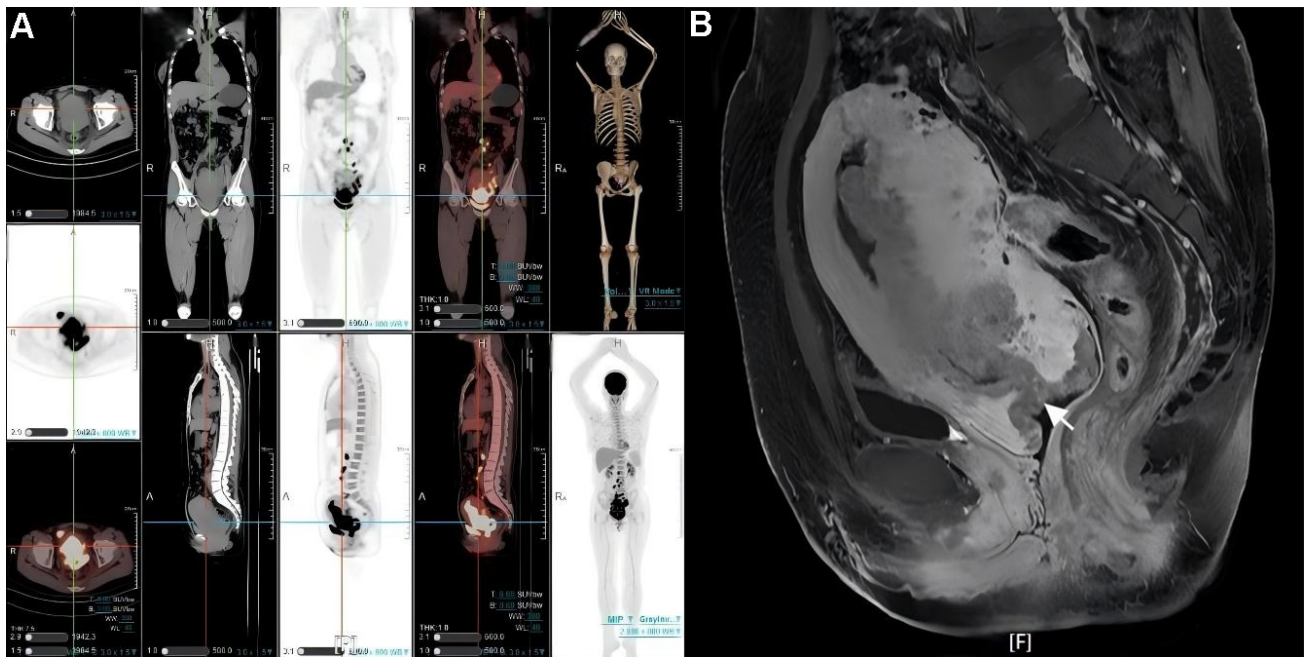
PET-CT and MRI show the location of the tumor. Imaging findings demonstrated an irregular hypodense cervical lesion that extends superiorly into the uterine corpus and inferiorly involves the vaginal canal demonstrated by (A) PET-CT imaging and (B) pelvic MRI (The arrow designates a substantial mass lesion occupying the endocervical canal). PET-CT, positron emission tomography-computed tomography; MRI, magnetic resonance imaging.
